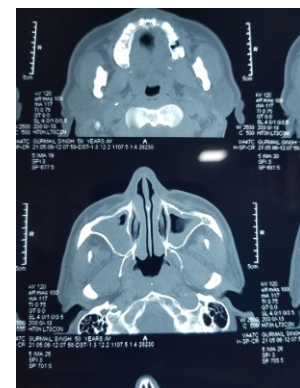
Coronal CT showing
